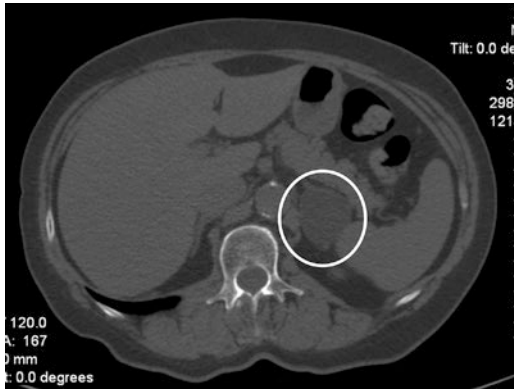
CT scan showing a left adrenal tumor that is hypodense in comparison with the liver. The tumor is homogeneous, encapsulated. No signs of malignancy
